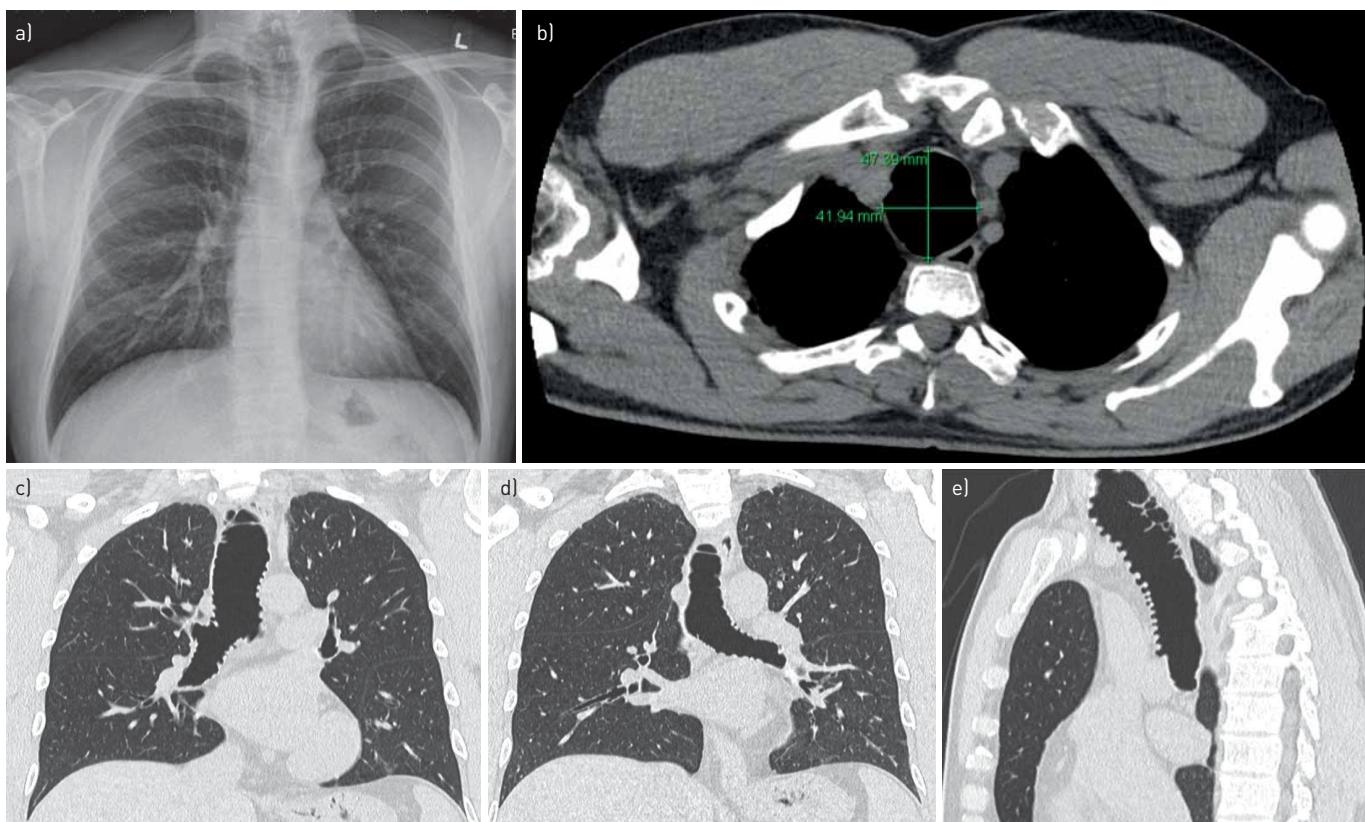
a) Chest radiograph (posterior-anterior) showing tracheomegaly. b) Computed tomography (CT) image of the trachea (axial view), largest diameter of trachea measuring 47mm×42 mm. CT image of the chest (coronal view) showing dilatation of c) right and d) left main bronchus. e) CT image of trachea (sagittal view) showing tracheal diverticula, septations and tracheomegaly.
